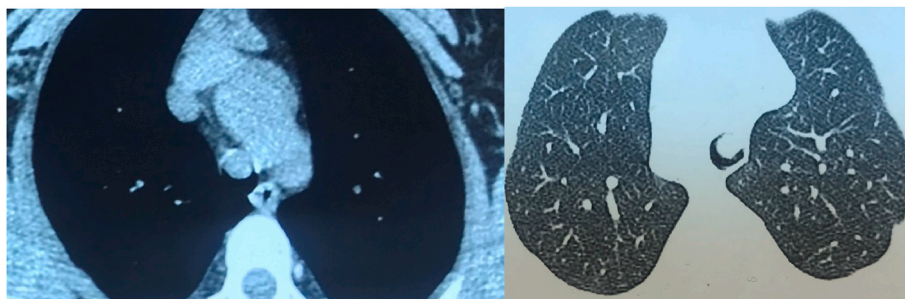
Computed tomography showing soft tissue mass arising from the anterior wall of the trachea and obliterating the lumen.
